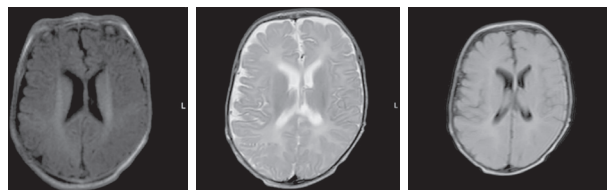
Magnetic resonance imaging of a patient at the age of 3 months. Axial sections, T1 VI, T2 VI, Flair. The signs of delayed myelination, were found to be symmetrical at the level of the perirolandic region. The architectonics of the furrows and convolutions have not been changed
